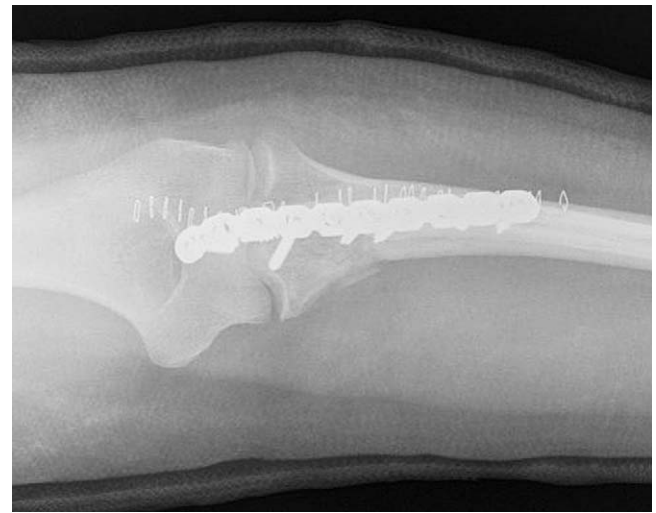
Antero-posterior radiograph of plating and screws for olecranon fracture.
